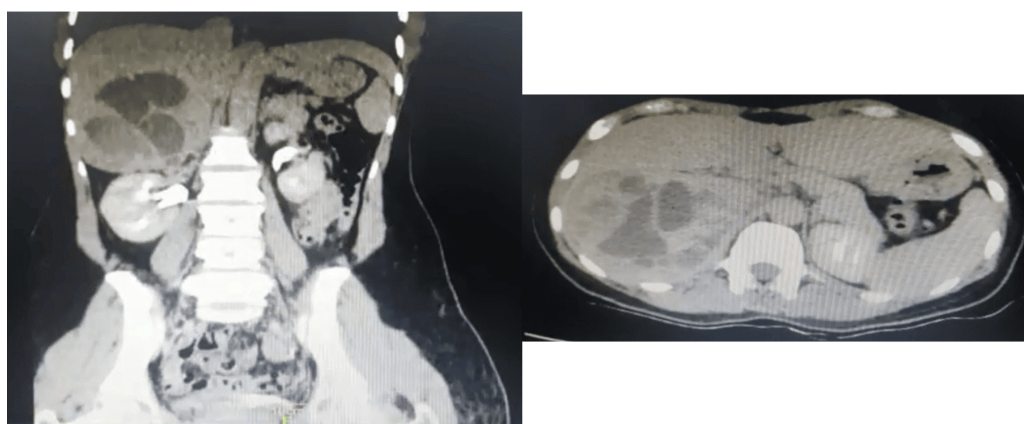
Contrast-enhanced abdominal CT scan showing a right multicystic adrenal mass
